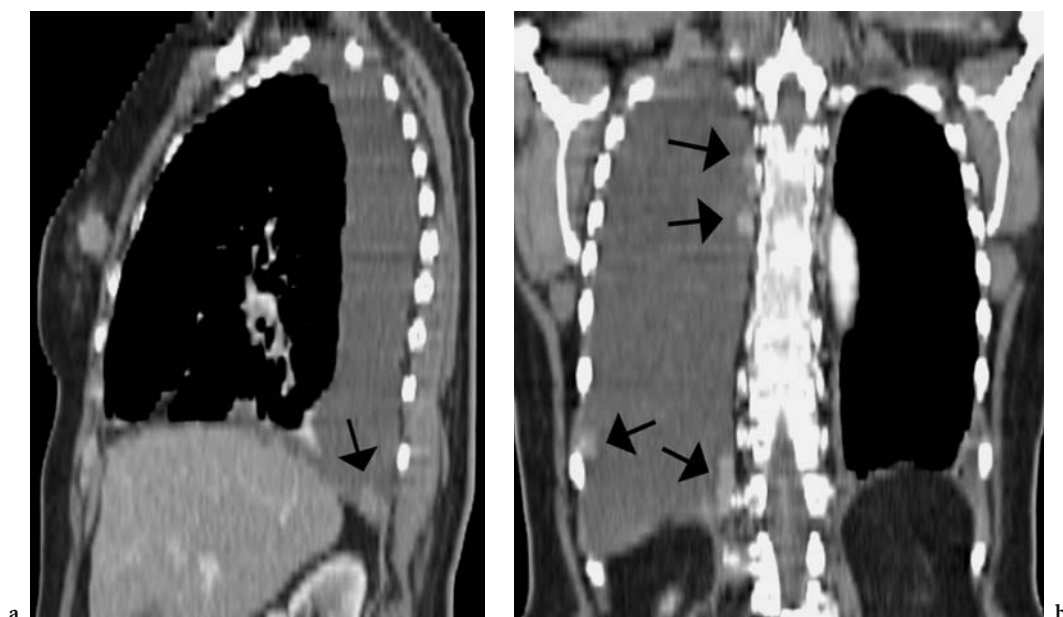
Malignant tumor of the breast. a Sagittal reformation shows the mass which is separated from the pectoralis muscle by a small amount of fat. On this sagittal image and also on the b coronal view an important pleural effusion and several pleural metastases are seen (arrows). The CT protocol: acquisition 4×2.5 mm; pitch 1.38; slice thickness for coronal and sagittal reformations 3 mm
